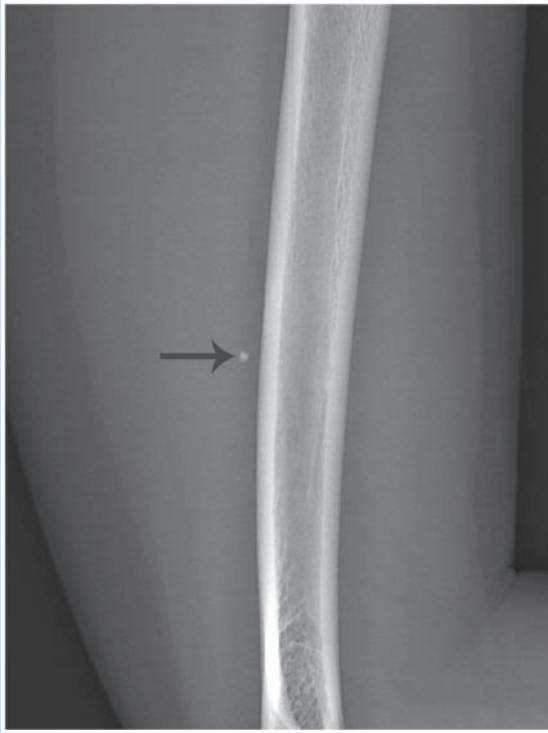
Lateral radiograph demonstrates a phlebolith (arrow) in a 31-year-old woman with an intramuscular hemangioma of the lateral triceps.
